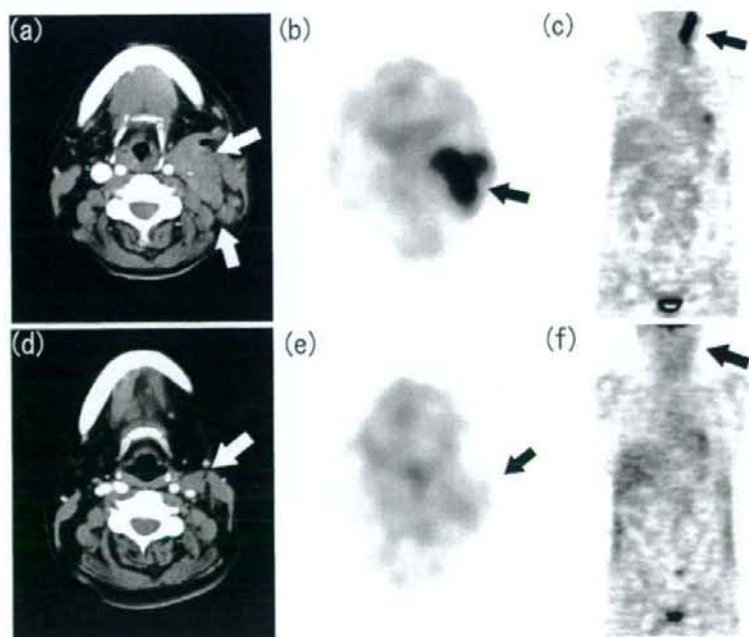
18 F-FDG-PET and CT images obtained for restaging (a–c) and evaluation of treatment response (d–f) in a 51-year-old woman with recurrence of lymphoplasmacytic lymphoma. Axial and coronal 18 F-FDG-PET images (b, c) obtained for restaging showing abnormal 18 F-FDG uptake in the left neck (black arrows), and the axial CT image (a) showing massive involvement in the left neck (white arrows). After chemotherapy, the axial and coronal 18 F-FDG-PET images (e, f) were negative (black arrows), but the axial CT image (d) showed residual soft-tissue density (white arrow). This patient was considered to be in complete remission on the basis of the clinical follow-up results
